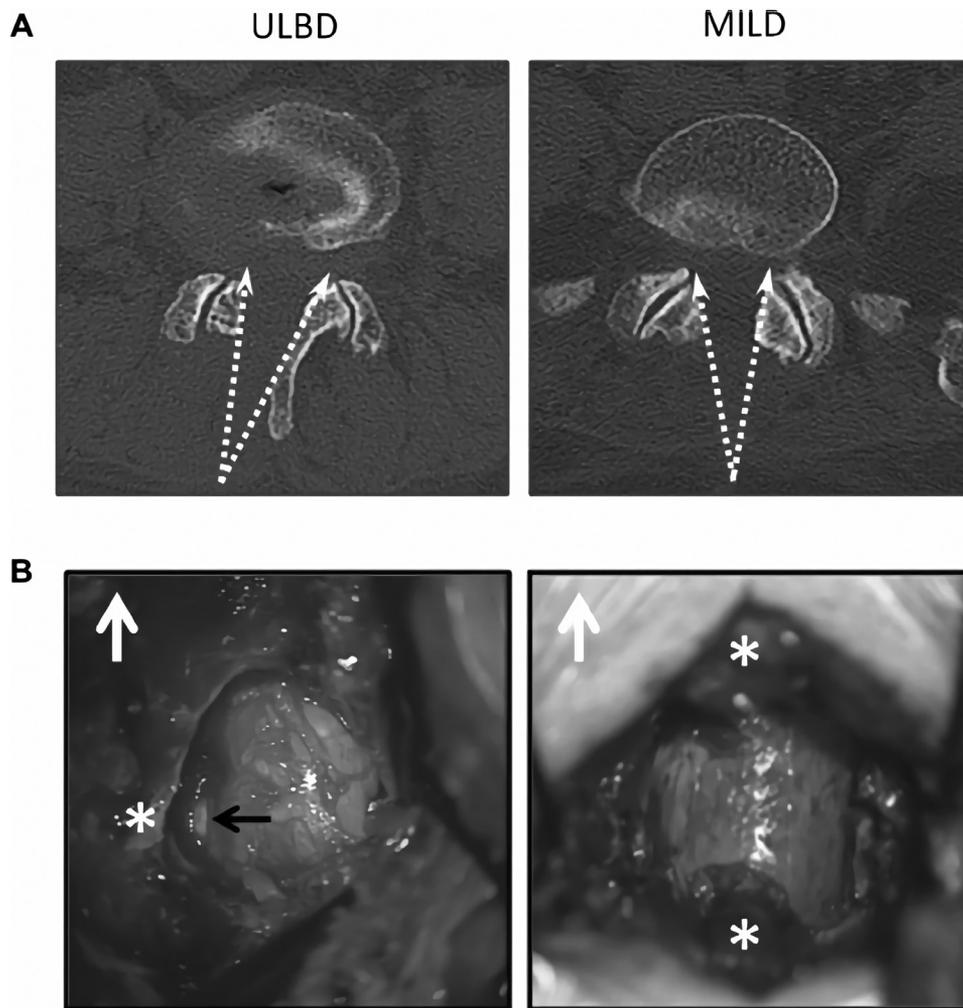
(A) Computed tomographic scans of ULBD and MILD procedures. In the approach of the ULBD, the paraspinal muscles were dissected from the midline and the interlaminar space was exposed. A laminotomy was performed by removing a portion of the superior and inferior laminae at the segment, and a small portion of the medial facet. Deep cortical surface of contralateral lamina was undercut and drilling was extended to the contralateral medial facet. In the approach of the MILD, the interspinous ligament is divided on the midline, and the operative field is broadened by laterally expanding the space between each split half of the ligaments. Partial laminotomy of the caudal half of the upper adjacent lamina, a dome-like expansion is performed by removing the inner laminar plate to the extent where the cranial margin of the ligamentum flavum is freed. (B) Intraoperative photographs of ULBD and MILD procedures. White arrows denote cranial side; black arrow, nerve root of the contralateral side in ULBD. *Spinous processes. ULBD indicated unilateral laminotomy for bilateral decompression; MILD, muscle-preserving interlaminar decompression. Reprinted with permission from Spine: Arai Y, Hirai T, Yoshii T, et al. A prospective comparative study of 2 minimally invasive decompression procedures for lumbar spinal canal stenosis: unilateral laminotomy for bilateral decompression (ULBD) versus muscle-preserving interlaminar decompression (MILD). Spine February 2014, 39(4) Fig. 1 (a and b).
